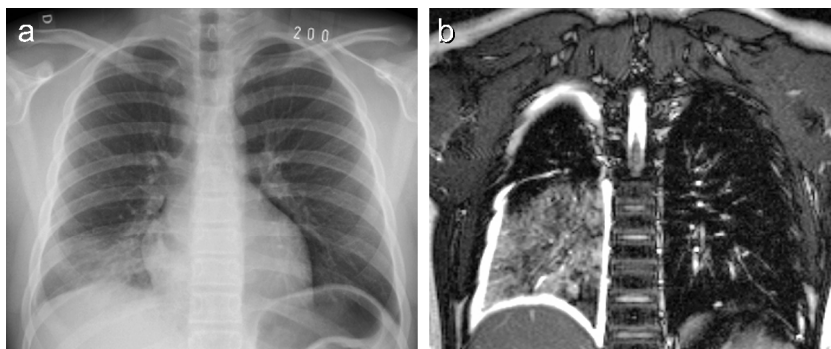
Pneumonia caused by *M. pneumoniae* in a 14-year-old boy. (a) Initial chest radiograph shows an infiltrate in the right lower lobe. (b) MRI done 2 days later. The T2-weighted coronal image shows parenchymal edema in the entire right lower lobe and pleural fluid collections (Figure adapted from an article by Peltola et al., in press).
